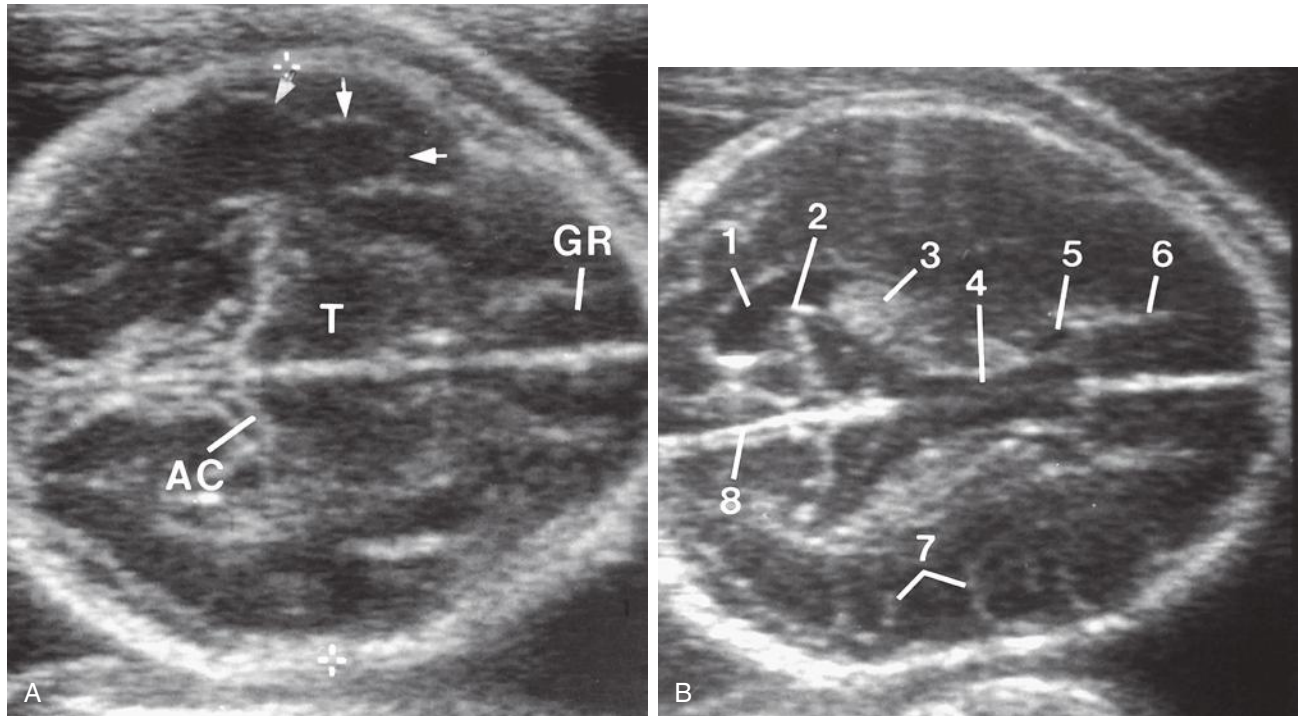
Transverse axial sonograms of a fetus with little calcification of the calvaria (recessive osteogenesis imperfecta). A, Note the lack of near calvarial reverberation artifact enabling visualization of the near temporal lobe (*short arrows*) with greater clarity than the far temporal lobe. AC, ambient cistern; GR, gyrus rectus; T, thalamus. B, Note the clarity which with the near ventricle is visualized. 1, occipital horn; 2, calcar avis; 3, atrial choroid; 4, corpus callosum (it is very unusual to see so much of the corpus callosum in an axial plane); 5, frontal horn; 6, deep medullary veins; 7, sulci; 8, falx cerebri.
